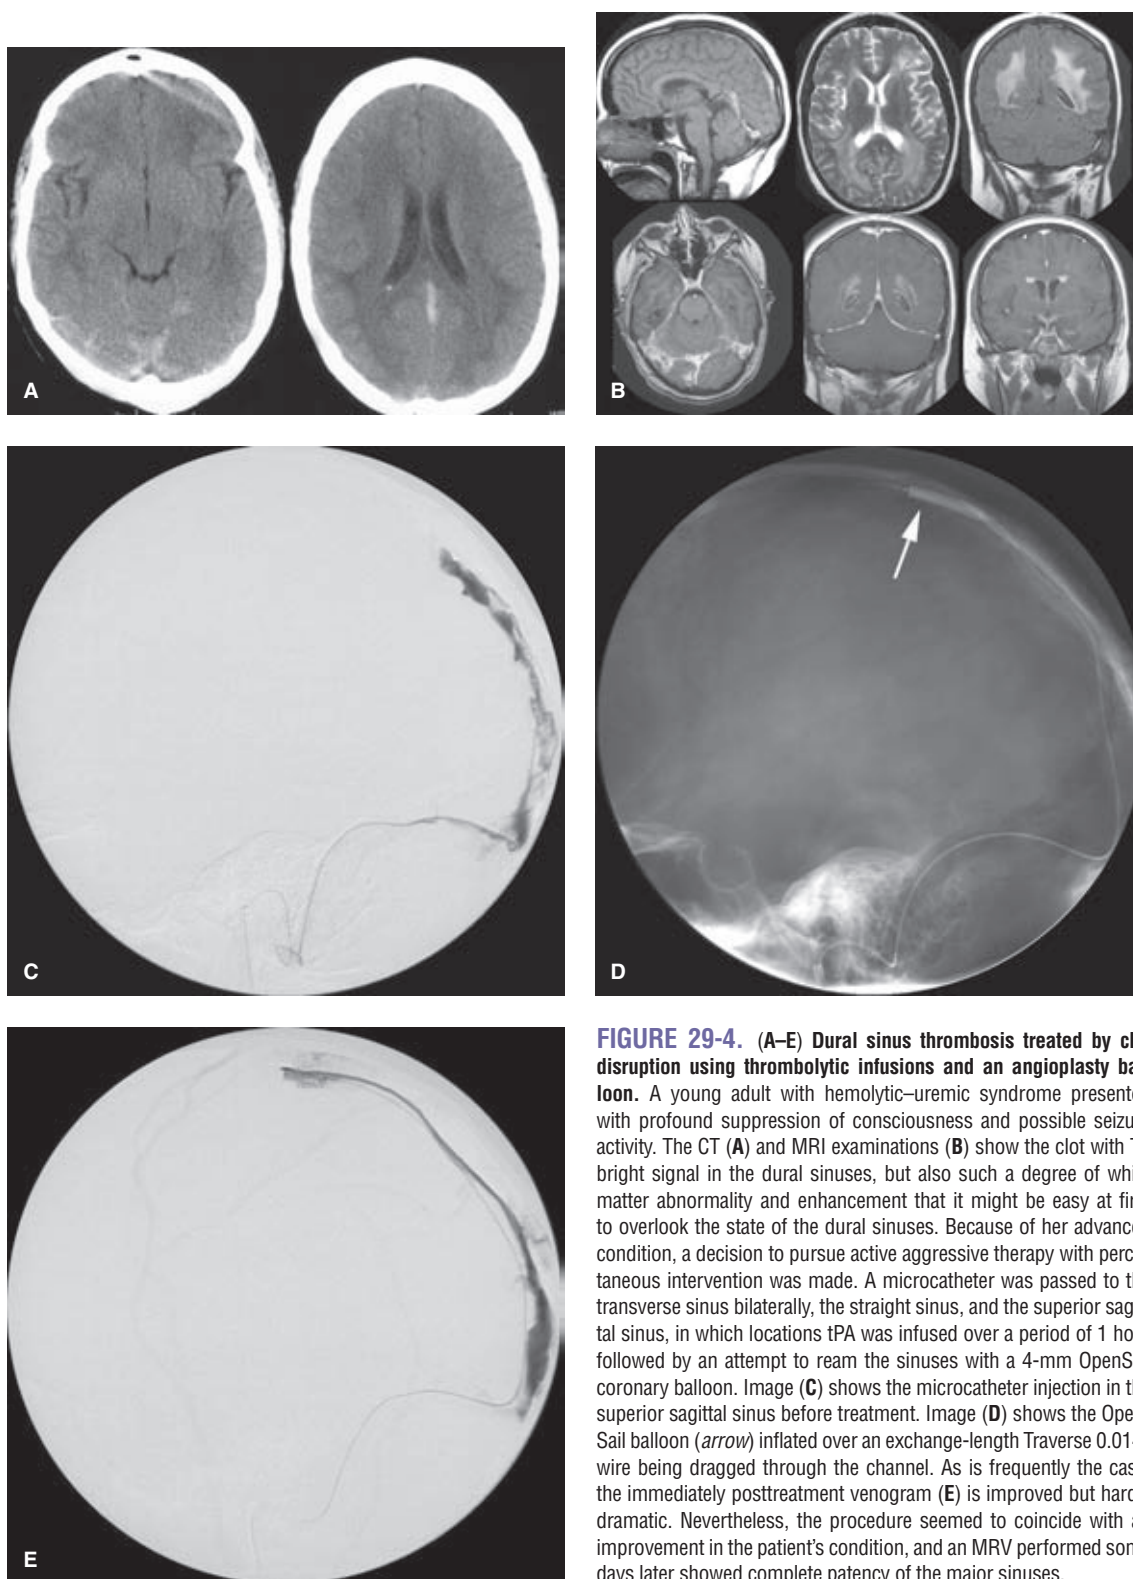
(A–E) Dural sinus thrombosis treated by clot disruption using thrombolytic infusions and an angioplasty balloon. A young adult with hemolytic–uremic syndrome presented with profound suppression of consciousness and possible seizure activity. The CT (A) and MRI examinations (B) show the clot with T1 bright signal in the dural sinuses, but also such a degree of white matter abnormality and enhancement that it might be easy at first to overlook the state of the dural sinuses. Because of her advanced condition, a decision to pursue active aggressive therapy with percutaneous intervention was made. A microcatheter was passed to the transverse sinus bilaterally, the straight sinus, and the superior sagittal sinus, in which locations tPA was infused over a period of 1 hour followed by an attempt to ream the sinuses with a 4-mm OpenSail coronary balloon. Image (C) shows the microcatheter injection in the superior sagittal sinus before treatment. Image (D) shows the OpenSail balloon (*arrow*) inflated over an exchange-length Traverse 0.014” wire being dragged through the channel. As is frequently the case, the immediately posttreatment venogram (E) is improved but hardly dramatic. Nevertheless, the procedure seemed to coincide with an improvement in the patient’s condition, and an MRV performed some days later showed complete patency of the major sinuses.
